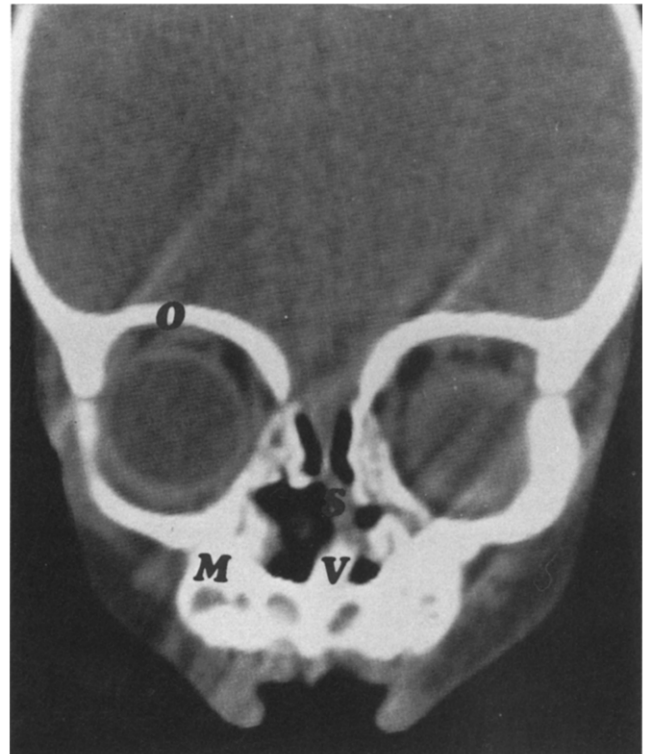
CT of a 2-year-old infant. S, nasal septum (deviated); V, vomer; M, maxilla; O, orbital roof. Note persistent 'defect' in lamina cribrosa. (Philips Tomoscan 350, section thickness 1.5 mm)
